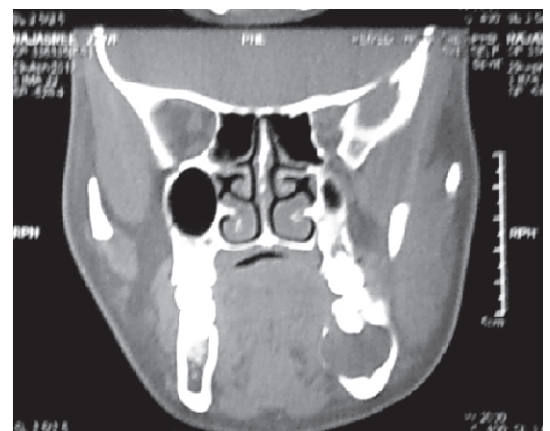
Coronal view of CT Scan shows an osteolytic lesion causing expansion of buccal & lingual cortical plates in the left of mandible
